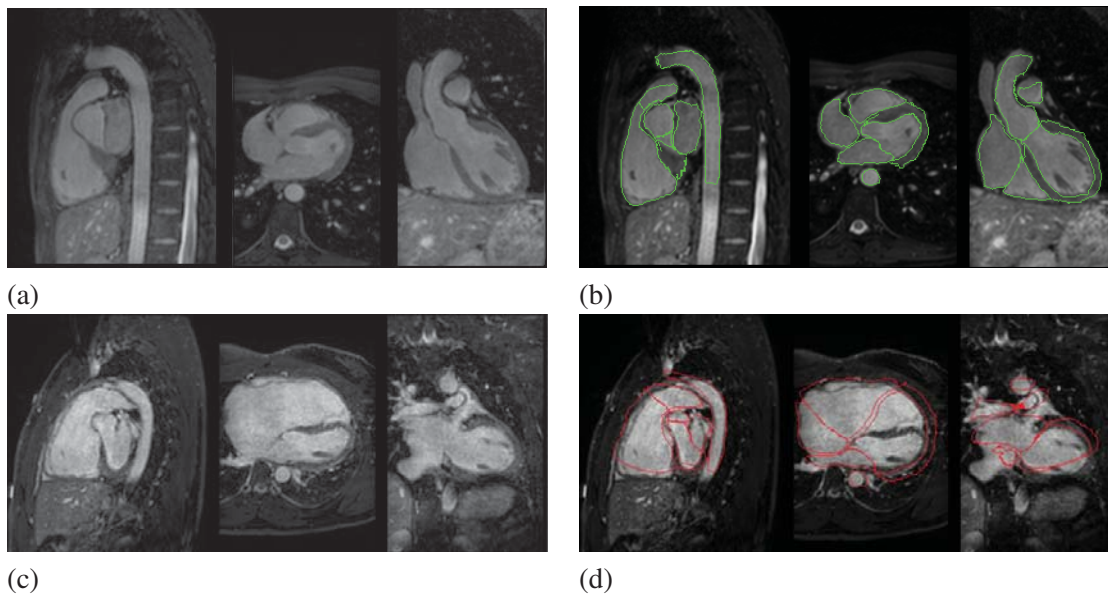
(a) The three views (sagittal, axial, and coronal views) of an MR image from a healthy volunteer; (b) the corresponding three views of a successful segmentation, defined by the green contour, superimposing on (a); (c) the three views of an MR image from a patient with right ventricle hypertrophy; (d) the corresponding three views of an erroneous segmentation, defined by the red contour, superimposing on (c). MR data from Guy’s and St Thomas’ Hospital, London.
